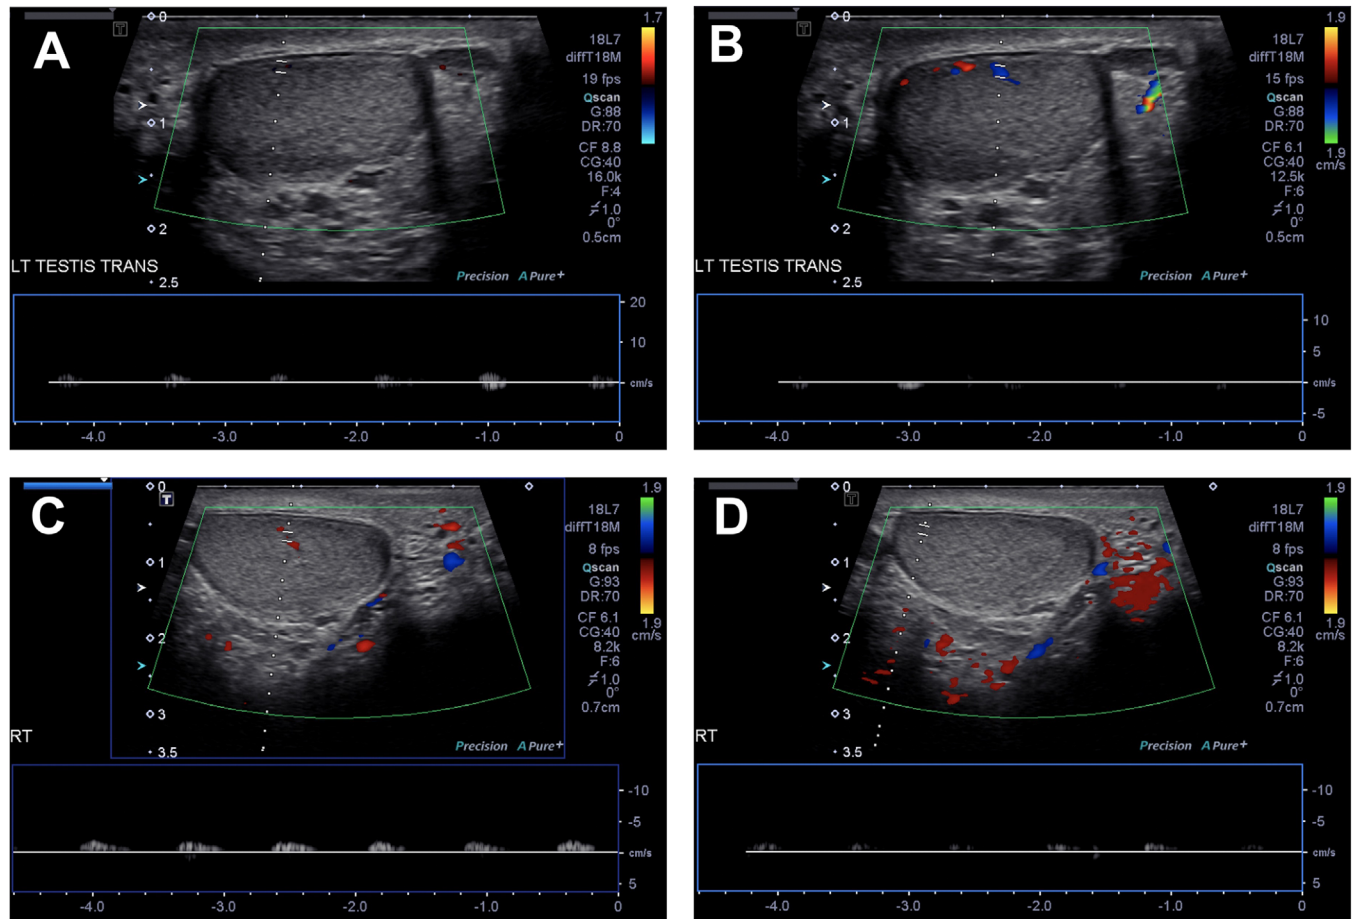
Diminished arterial flow on doppler ultrasound noted in different portions of the left testicle (A and B) and right testicle (C and D)
